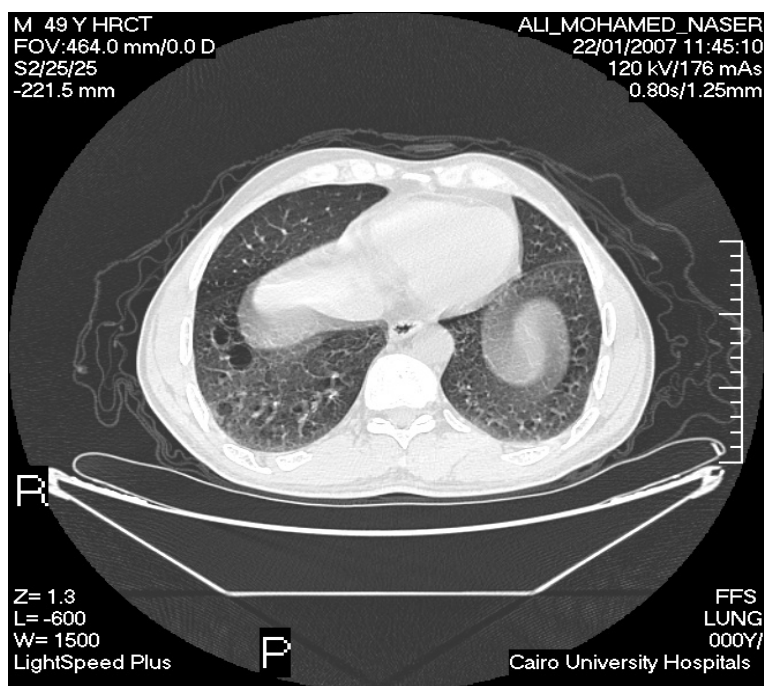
HRCT chest of case (no.3) A 48 year old male patient with HCV infection. Smoking index was 100. He complained of morning cough & expectoration. Chest auscultation revealed vesicular breathing with prolonged expiration. This cut of HRCT revealed bilateral lower zonal groundglass attenuation and right basal cystic changes the rest of the cuts showed peripheral cicatricial emphysema. He took a score of 4.
